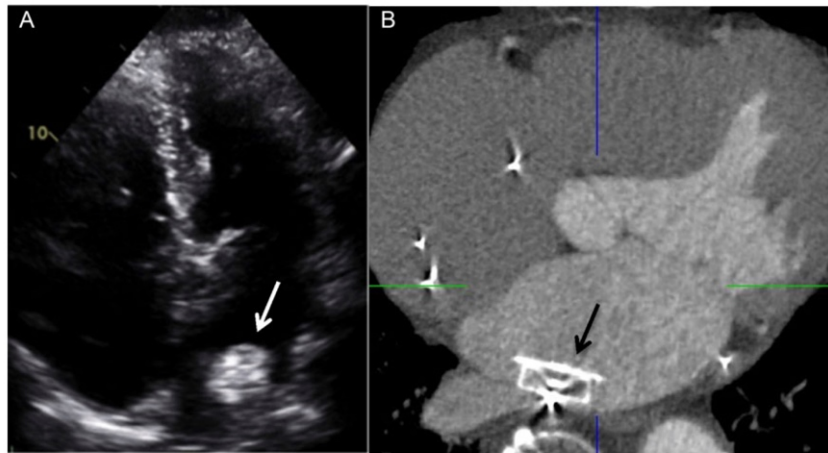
Embolized ACP device in the left atrium that was lodged posteriorly, seen on (A) TTE (white arrow) and confirmed on (B) contrast-enhanced four-chamber CT image (black arrow).
